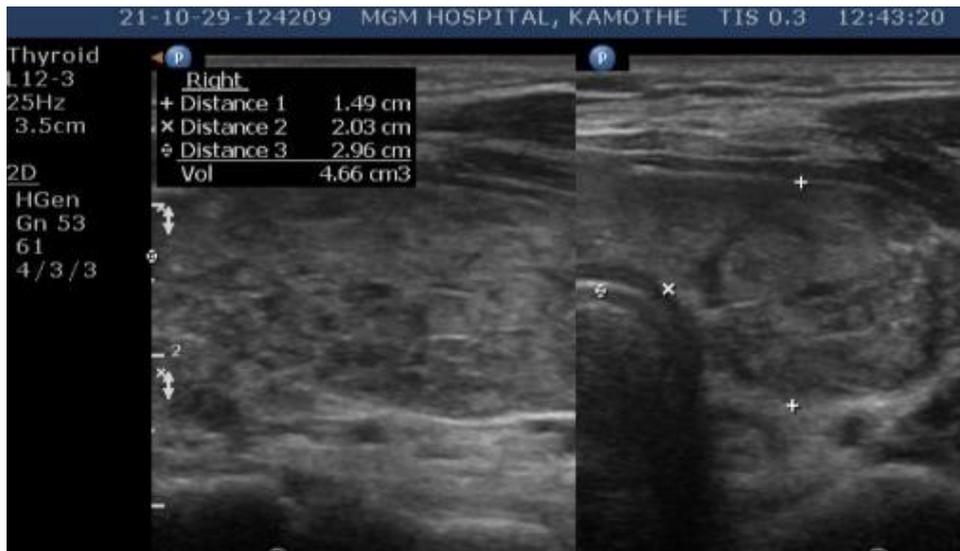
Ultrasound of Multinodular Goitre
